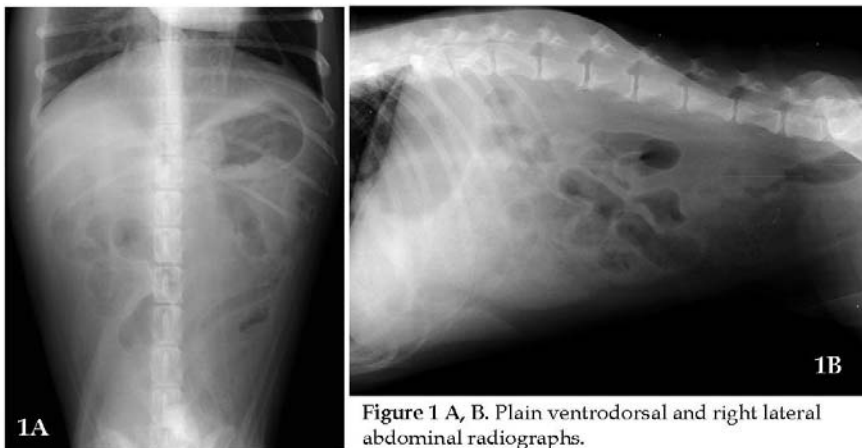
A, B. Plain ventrodorsal and right lateral abdominal radiographs.
